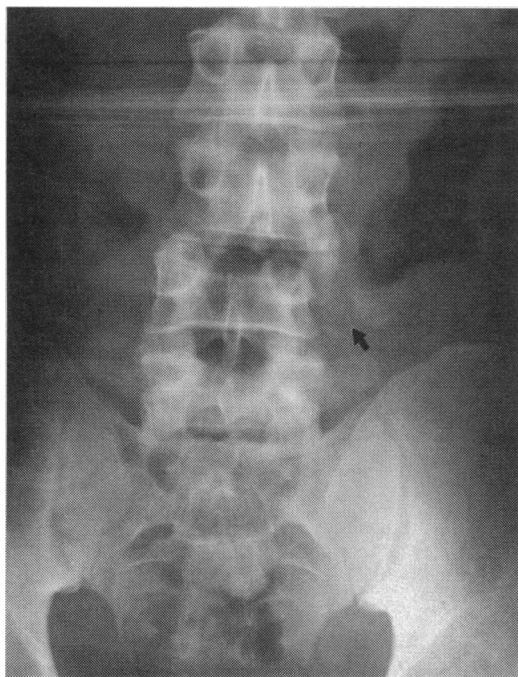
Anteroposterior radiograph of the lumbar vertebrae showing a crush fracture of L4 with rotation of the spinous processes of L2 and L3 to the right. There is also a fracture of the transverse process of L4.
